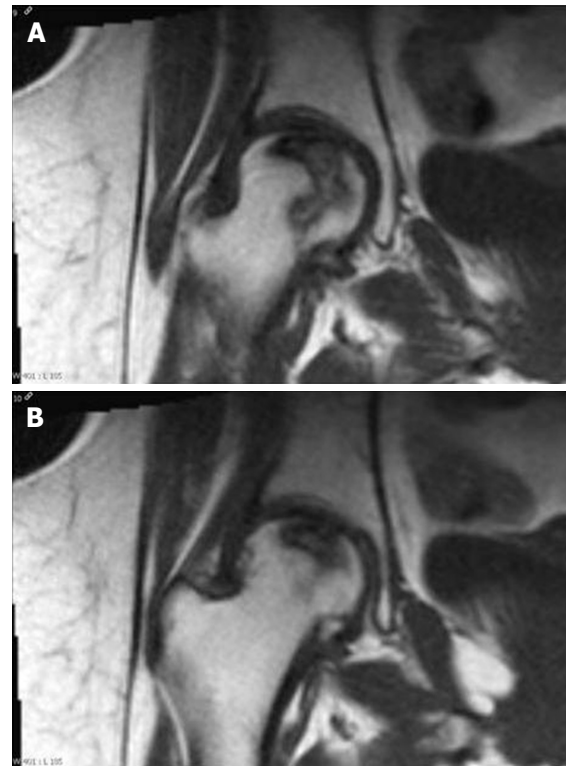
Two adjacent coronal T1-weighted images show the discrepancy between the two parameters (volume, A vs surface area, B) considered for the prediction of future joint deformity. Even if the overall necrotic lesion is rather big (A), there is only a minor involvement of the femoral head surface (B): In these cases RV performed better than RS in predicting femoral head deformity. RV: Relative volume; RS: Relative surface.
